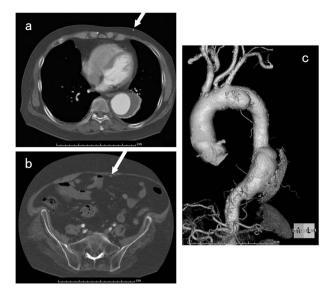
(a) Preoperative computed tomography (CT) shows a saccular aneurysm (maximum diameter, 68 mm) in the descending thoracic aorta and ventriculoperitoneal shunt (arrow). (b) Preoperative CT shows stenosis of bilateral iliac arteries and ventriculoperitoneal shunt (arrow). (c) Preoperative three-dimensional-volume-rendering CT angiography shows descending aortic aneurysm, small distal arch aneurysm, and neck vessels.
